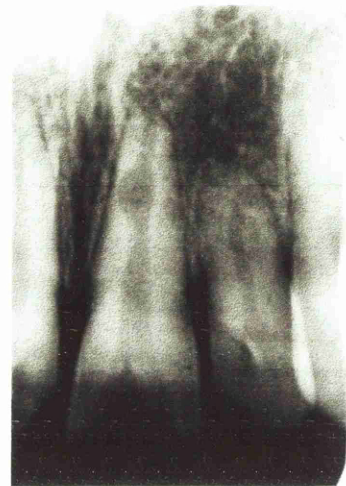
Periapical radiographs of maxillary left lateral incisor (22) in a 16 year old girl following subluxation injury (E.C.- ethyl chloride, E.P.T.- electric pulp test, LDF- laser doppler flowmetry diagnosis).
